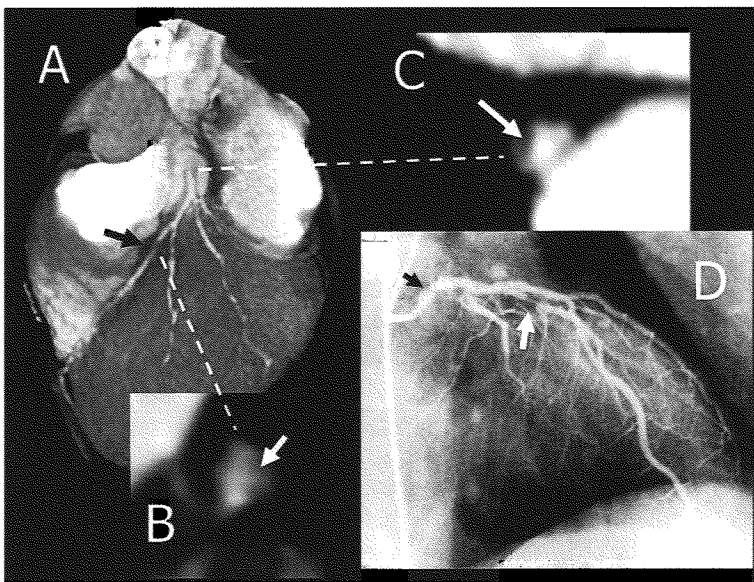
A 33-year-old man with unstable angina. Volume rendering image (A) shows stenosis in the left anterior descending artery (arrow) and a cross-sectional multiplanar reformation (MPR) image (B) shows high-grade stenosis with a CT-low-density plaque (44 HU, arrow). Cross-sectional MPR image of the left main coronary artery (C) also exhibits mild stenosis with a CT-low-density plaque (14 HU, arrow). Coronary angiography demonstrates high-grade stenosis in the left descending artery (white arrow) and mild stenosis in the left main coronary artery (black arrow).
